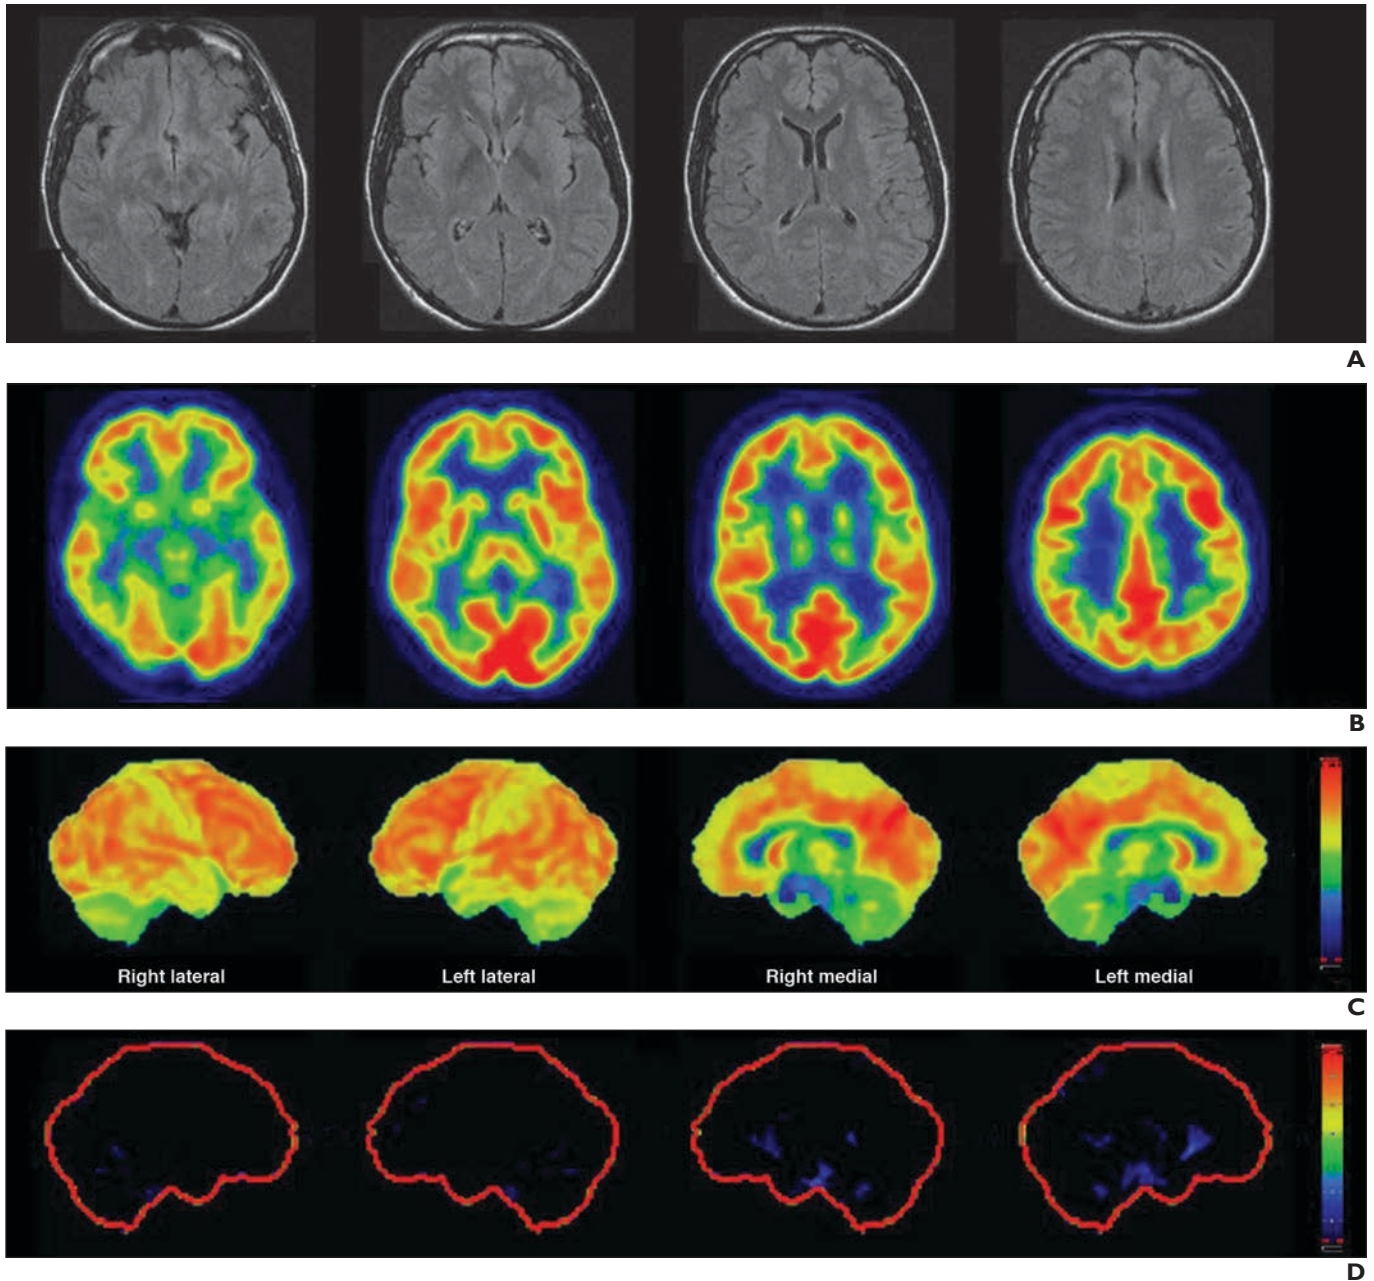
Pseudodementia in 57-year-old woman who presented with progressive cognitive decline and history of depression. A–D, Axial FLAIR MR images (*images from left to right* A): base to vertex), axial FDG PET images (B), 3D stereotactic surface projection maps (C), and sagittal Z-score maps (D) show normal findings. Both MRI and PET studies show normal findings. Nonspecific pattern of diffuse cortical hypometabolism can be seen with pseudodementia.
